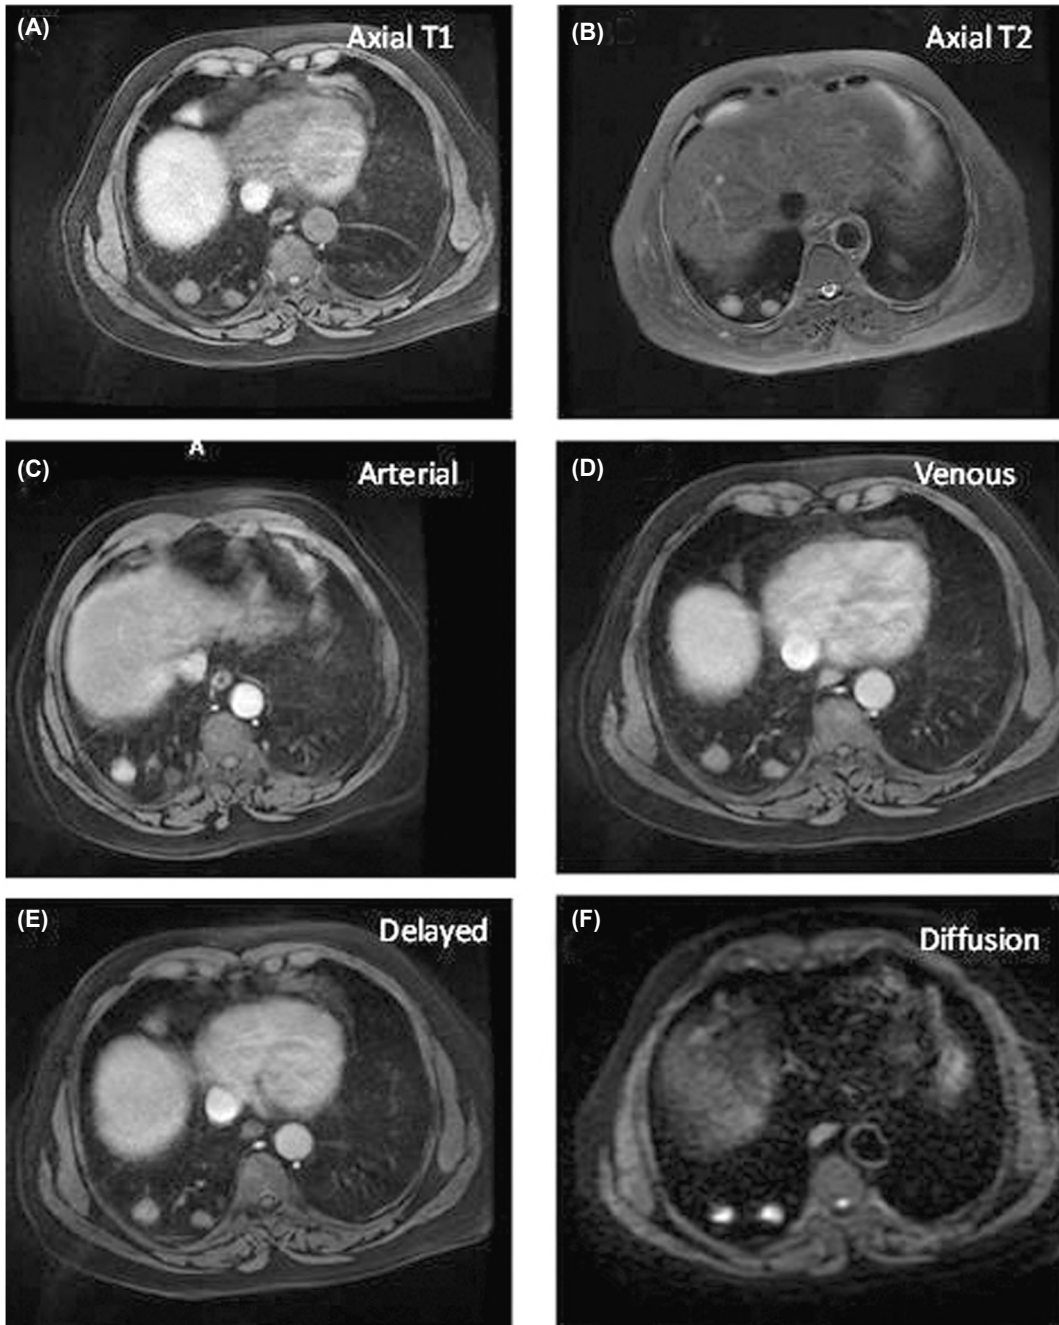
A 62-year-old male and a known case of metastatic cancer prostate. His X-ray revealed suspected pulmonary nodules seen at the right lower lung zone. His MRI confirmed two pulmonary nodules at the right lower lung lobe with the largest one measured 2.2 X 1.8cm, and the other measured 1.5 X 1cm. The nodules displayed isointense signal at T1WI (A) & T2WI (B). After dynamic post contrast phases that lasts for 4 minutes, the nodules showed arterial enhancement (C) and washout at subsequent phases (D,E). The ADC value was $1.2 \times 10^{-3} \text{ mm}^2/\text{s}$ with restricted diffusion (F) (nodules are bright). The time-enhancement curve was of type B (G).
